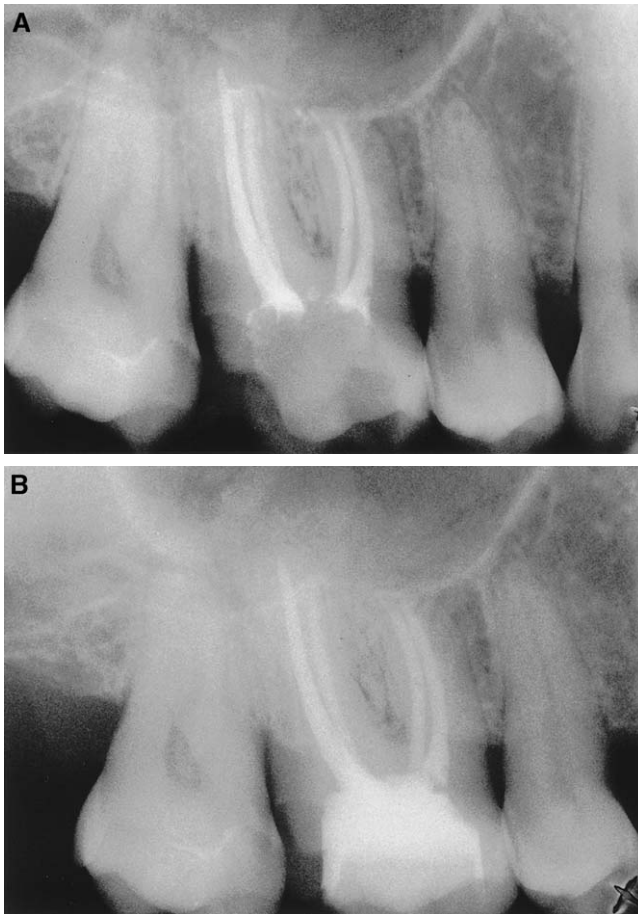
(A) Radiograph of the final fill (lateral condensation) of four canals in a maxillary first molar prepared with LightSpeed instruments using the “Zurich technique” (December 12, 1996). MAR in the four canals was size 47.5 (case supplied by Dr. A. Bindl). (B) Five-year follow-up radiograph of the maxillary first molar shown in Fig. 7A (February 24, 2003). MAR in all four canals was size 47.5 (case supplied by Dr. A. Bindl).
